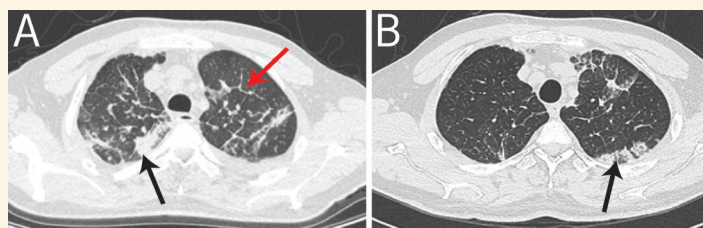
Chest high-resolution computed tomography axial views of a 39-year-old male patient showing (A) bilateral ground glass and airspace opacity (black arrow) associated with interlobular septal thickening (red arrow) and (B) two months post-initial scan showing improvement of the previously seen airspace opacities and new airspace opacities (black arrow).
